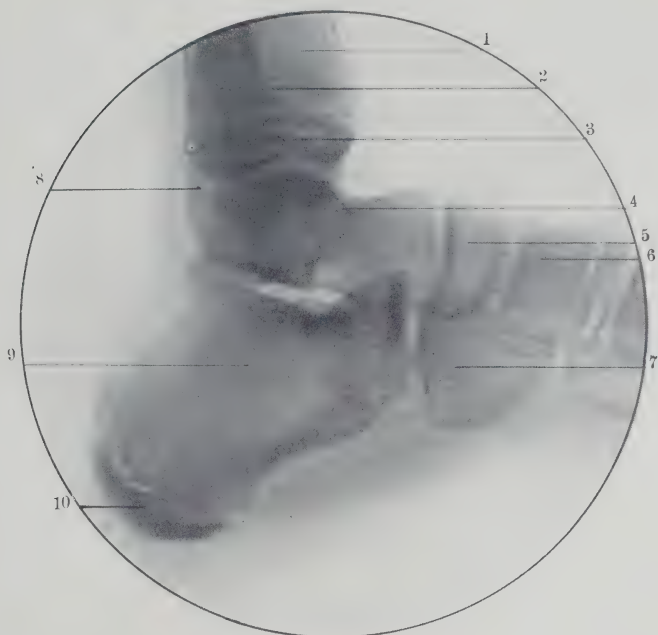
Radiograph Showing Lateral View of Ankle at Thirteen Years. 1, Tibia; 2, fibula; 3, lower epiphysis of tibia; 4, astragalus; 5, scaphoid; 6, internal cuneiform; 7, cuboid; 8, lower epiphysis of fibula; 9, os calcis; 10, epiphysis of os calcis. (Original.)
